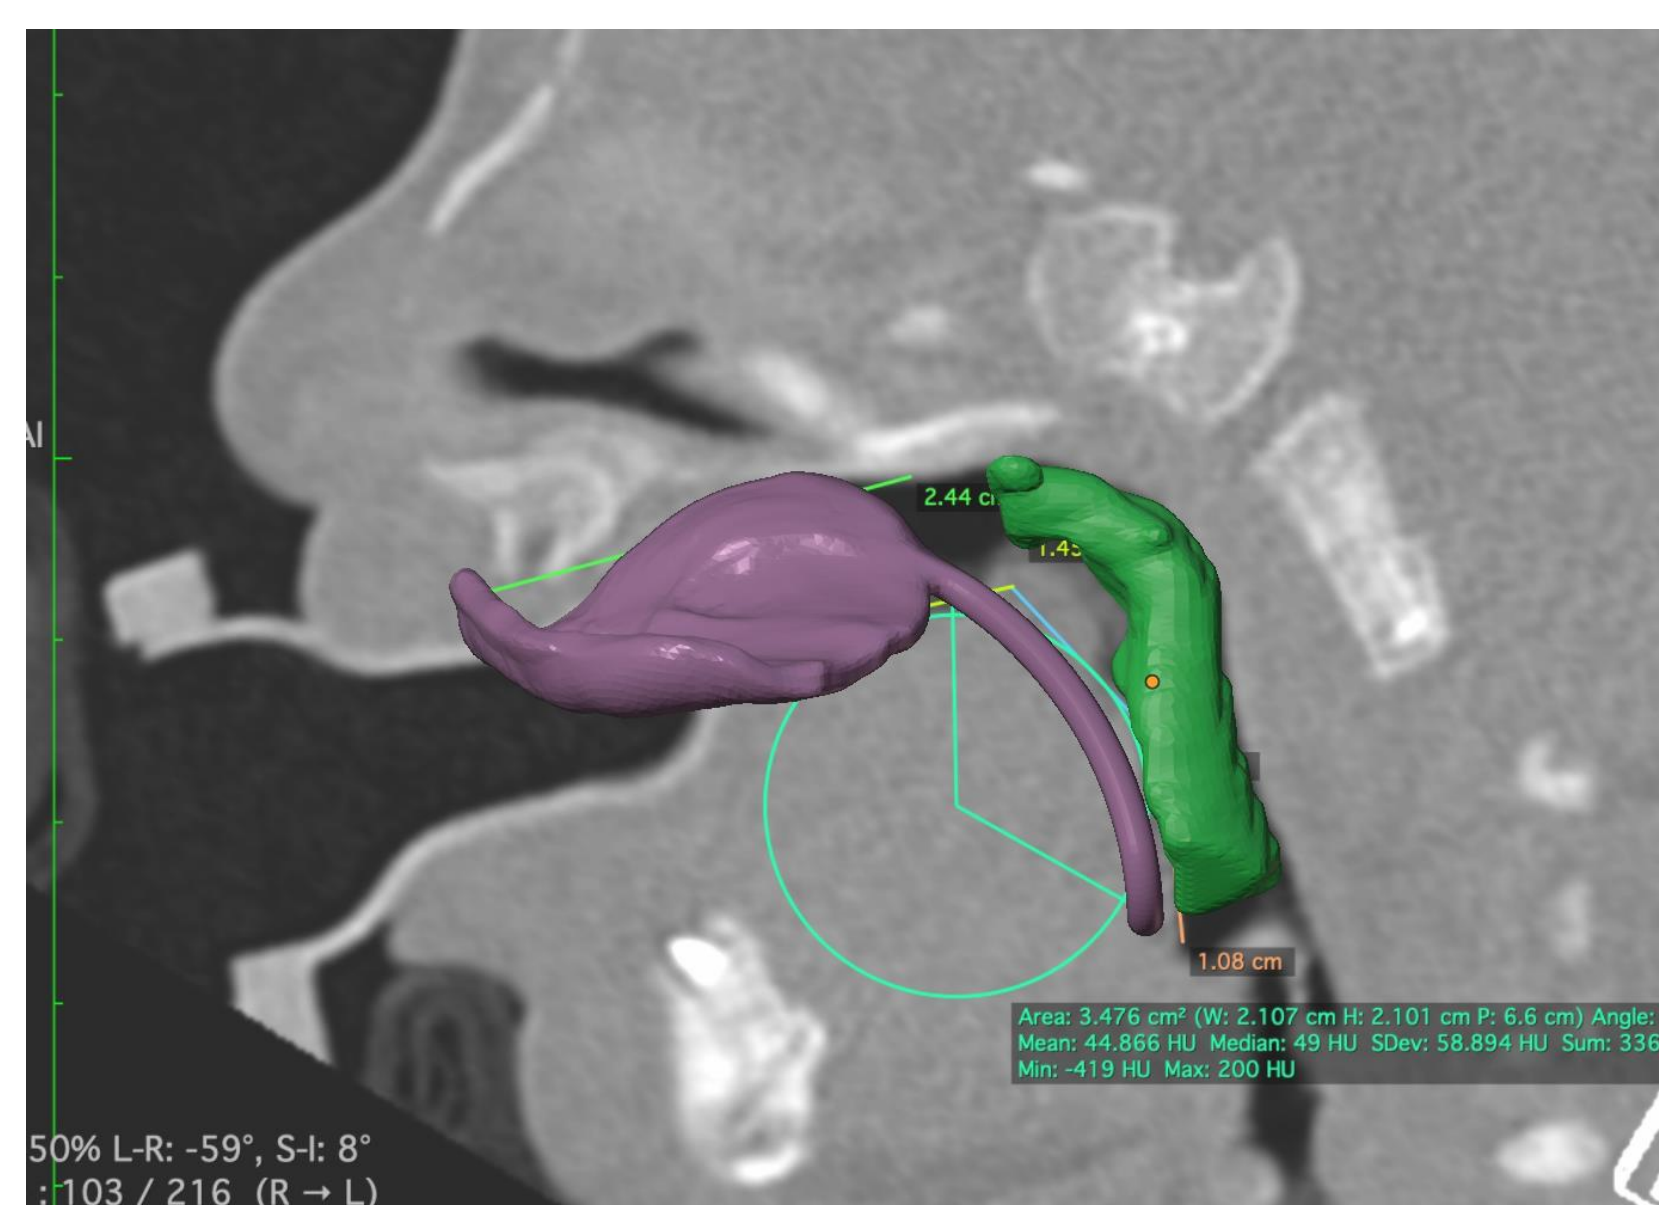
Device designed completely digitally in Blender. Purple is digitally designed device, green is model of constricted airway extracted from CT scan.
